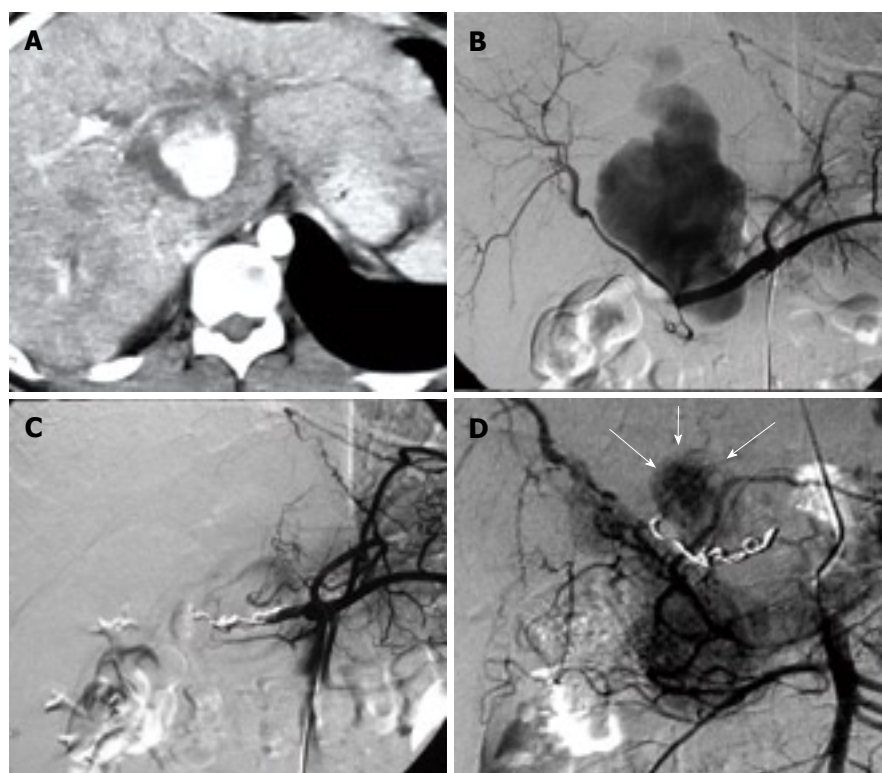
CT and angiography images. A: contrast enhanced CT revealing a collection filled of contrast at the hepatic hilum compatible with pseudoaneurysm and dilated intrahepatic bile duct; B: Selective arteriography of the celiac trunk showing the pseudoaneurysm arising from the common hepatic artery; C: Angiography of the common hepatic artery after embolization. No fill of the pseudoaneurysm is visible from this artery; D: Selective superior mesenteric artery arteriography three days after embolization. The pseudoaneurysm (white arrows) is partly thrombosed with persistence of filling from thin branches. The superselective catheterization of these vessel wasn't possible due its tortuosity and narrow caliber.
